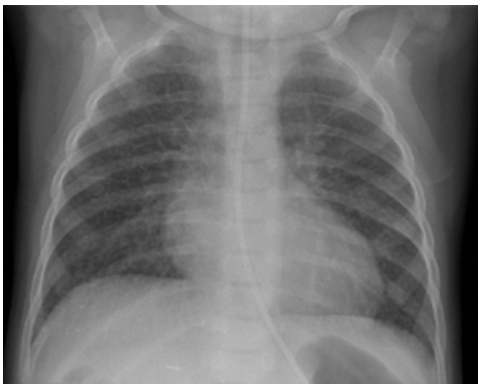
Chest X-ray showing bilateral interstitial shadowing and nodularity.
